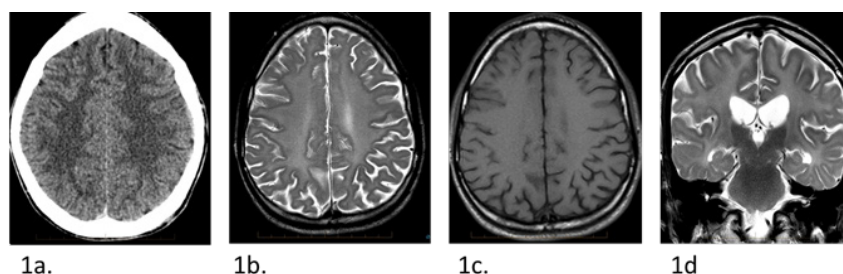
Representative axial and coronal slices of CT and MRI imaging of brain from 2009, 2016 to 2022. (1a) Initial axial non contrast CT obtained in 2009 (age 19), reveals diffuse confluent hypodensity in bilateral cerebral white matter; (1b) Axial MRI T2 weighted MRI in 2016 (age 27), reveals diffuse confluent symmetric increased signal in the cerebral white matter; and (1c) white matter signal abnormality is not evident on the axial T1 weighted sequence; (1d) Coronal T2-weighted MRI in 2022 (age 32), reveals similar diffuse hyperintense signal in supratentorial white matter.
